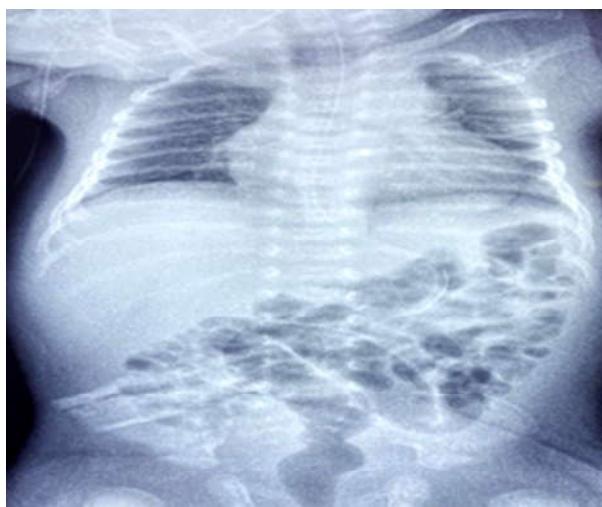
Chest X-Ray(AP view) showing pericardial effusion and chest wall edema.
